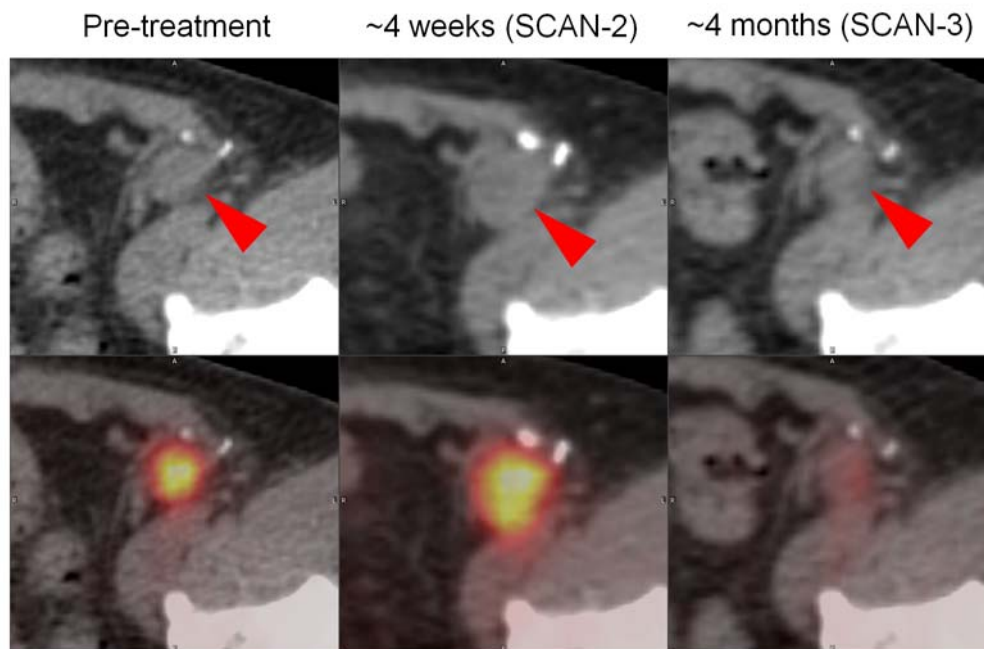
PET/CT scan images demonstrating representative changes in a melanoma inguinal lymph node metastasis (red arrowheads) at 4 weeks and 4 months after initiation of ipilimumab. At about 4 weeks (SCAN-2), the sum of target lesion diameters assessed by CT scan (top row of images) increased by 18.6 percent (stable disease by RECIST 1.1 criteria). During that same interval, PET imaging revealed a 25.1 percent increase in SULpeak (PERCIST criteria). Imaging at approximately 4 months revealed a marked improvement in the FDG avidity of the inguinal lymph node metastasis. A similar pattern was observed in this patient's other sites of disease, including hepatic, nodal and soft tissue metastases. The patient's metastases outside of the brain remained stable for 51 weeks.
